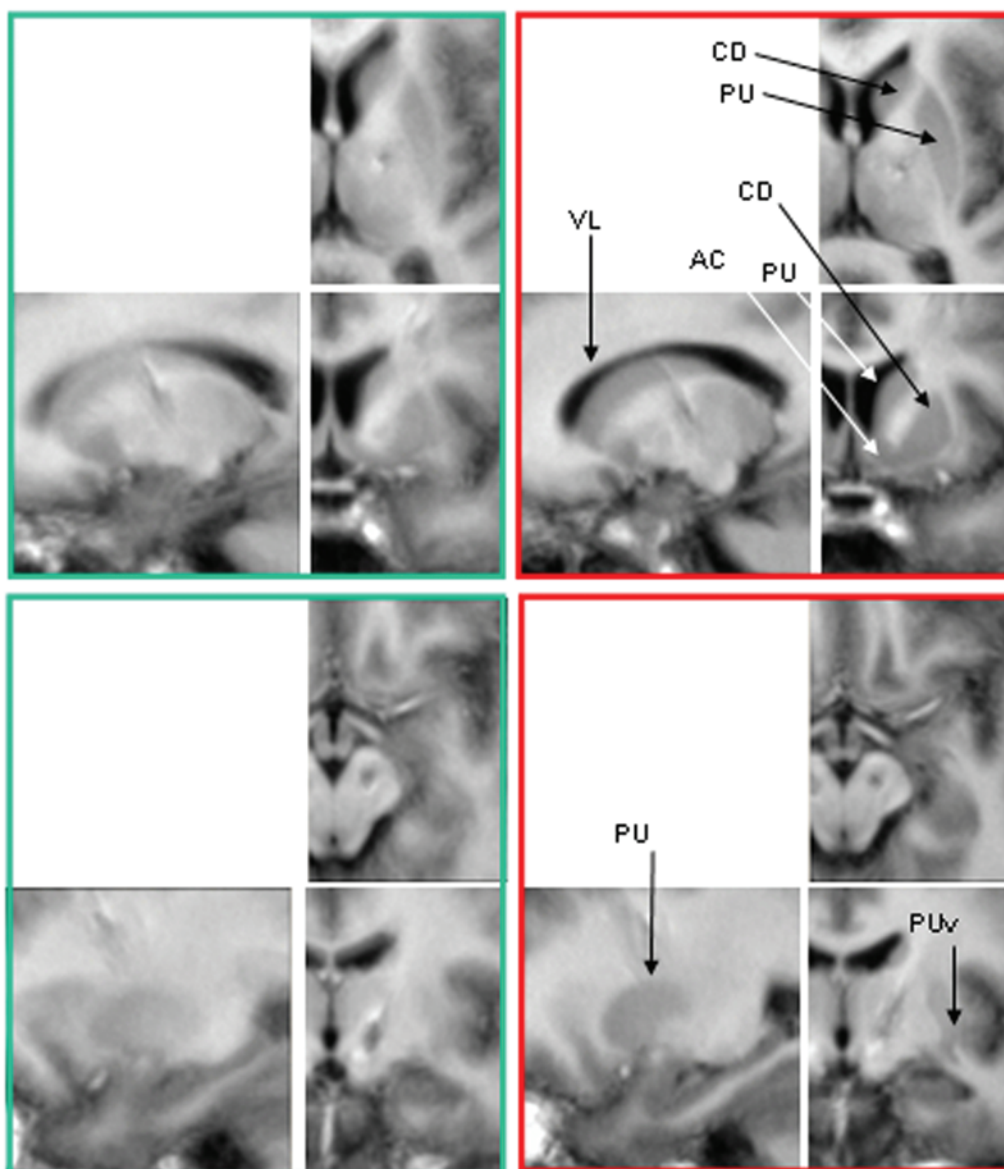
Average of spatially normalized MR images obtained in the 20 patients analyzed in this study. The *green boxes* showing AC-PC normalization, and the *red boxes* showing atlas normalization. *Upper*: Anterior, medial, and dorsal slices. *Lower*: Posterior, lateral, and ventral slices. Only 1 hemisphere is presented (the atlas is deformed independently on the 2 hemispheres). Note that the contours of gray level areas are sharper with atlas normalization. AC = nucleus accumbens; PUv = ventral putamen; VL = lateral ventricle.
